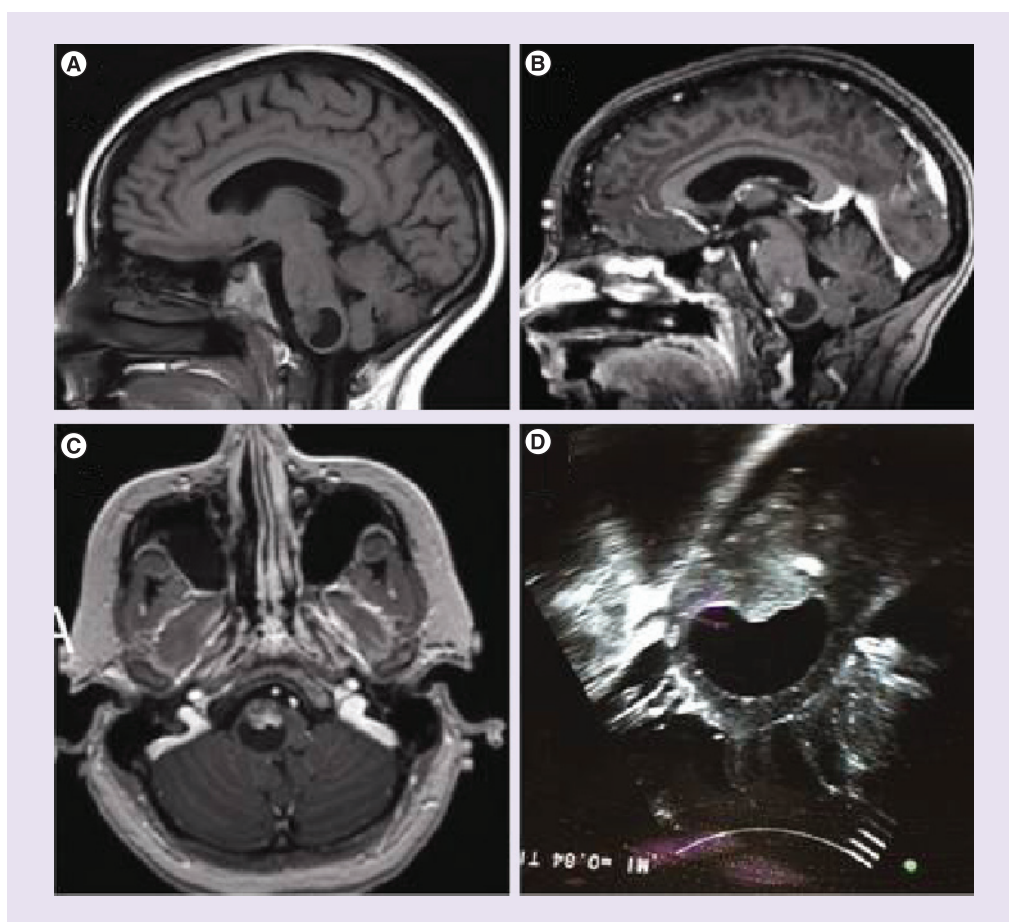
MRI scan and intraoperative ultrasound of a patient with a brainstem pilocytic astrocytoma. (A) Sagittal T1 without gadolinium; (B) Sagittal T1 with gadolinium; (C) axial T1 with gadolinium; (D) intraoperative ultrasound.
